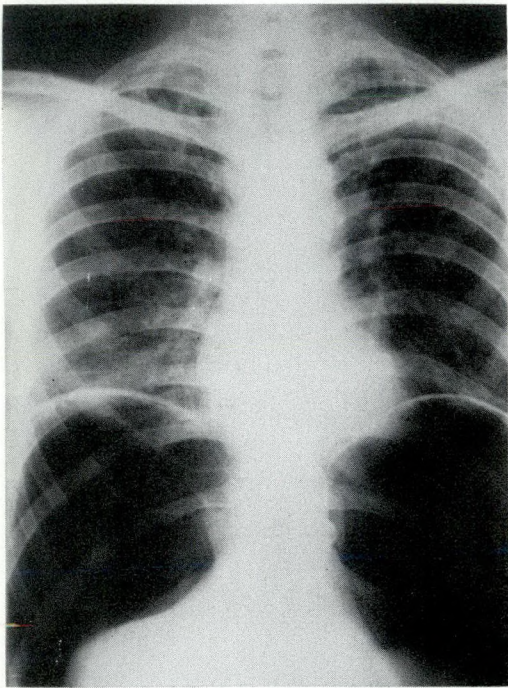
R. W. Chest radiograph June 10, 1953. A pneumoperitoneum has been established. Parenchymal disease has cleared well.
